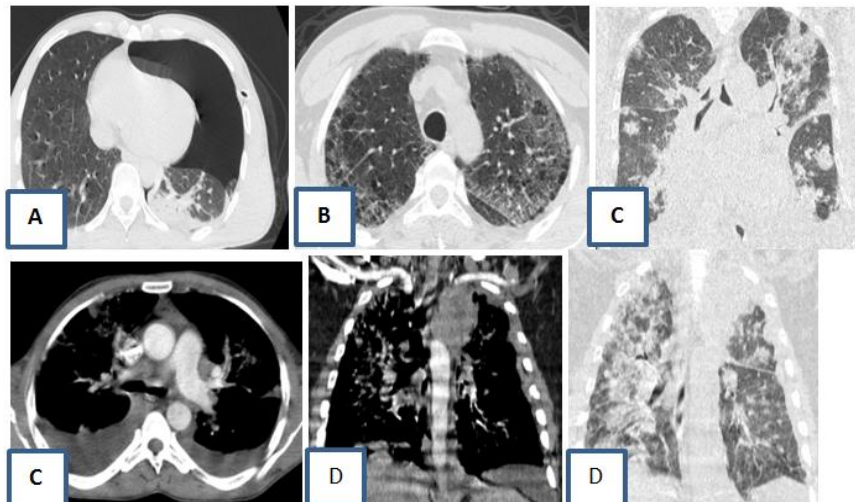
Chest CT with axial and coronal planes shows some association lésionnel with other pathology; A: Pneumothorax with covid 19; B: Histiocytosis X with covid 19; C: Lymphoma and pulmonary embolism with covid 19; D: Bronchial carcinoma with covid 19
